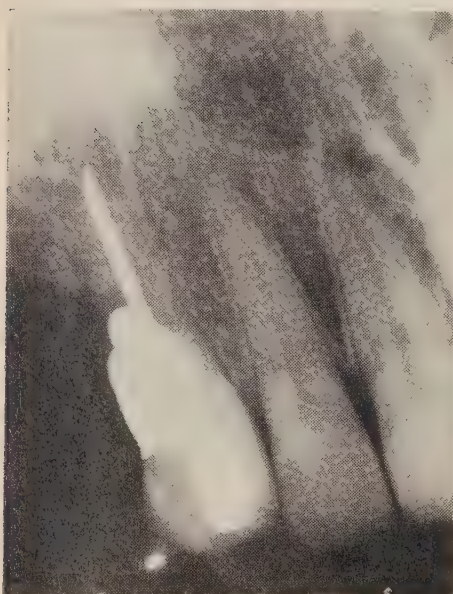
Radiographic appearance on recall examination in September 1968.
